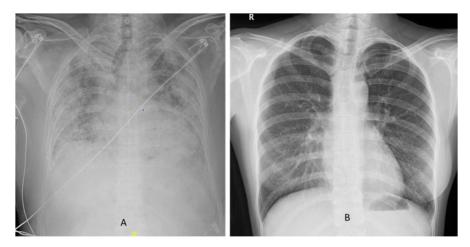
X-ray Chest showing interstitial shadows with reduced lung volume (A) and preserved lung volume (B)
